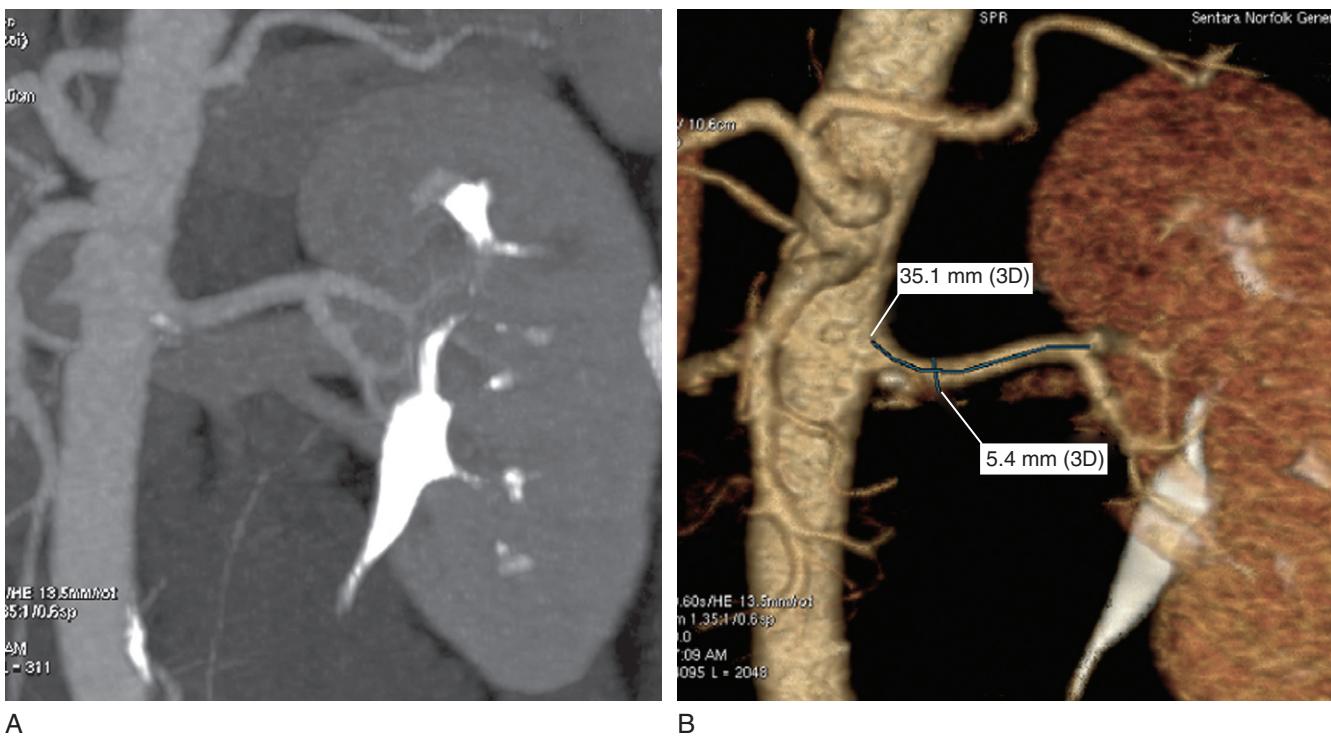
A*, Computed tomography angiography showing detailed vascular anatomy. *B*, Corresponding three-dimensional (3D) reconstruction.
